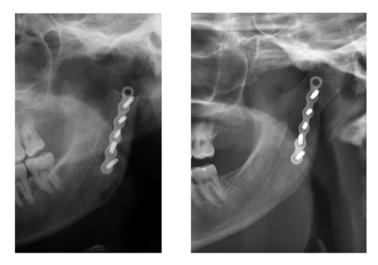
Left*: radiograph placement of CCRG. *Right*: radiograph 5 years later showing marked changes in rib that now looks like a normal condyle. In fact if one removed the titanium plate, you would not know that the person had a CCRG placed
